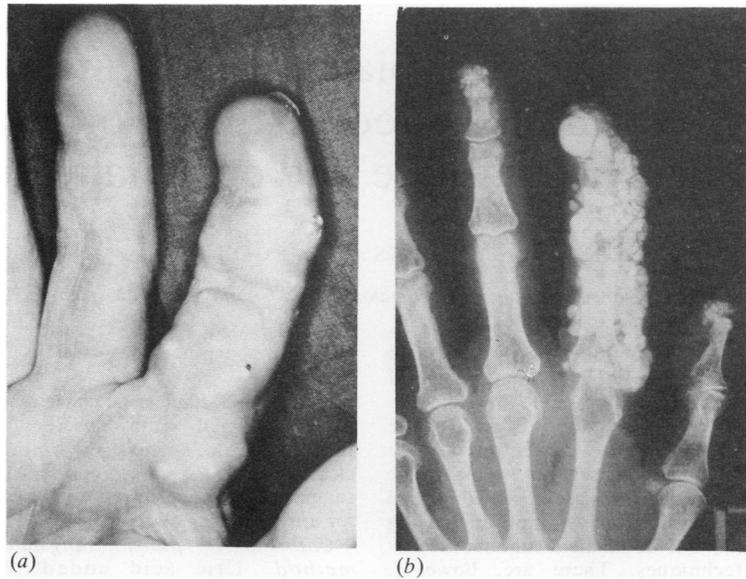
Clinical picture and radiograph of the right index finger (case No. 7).
